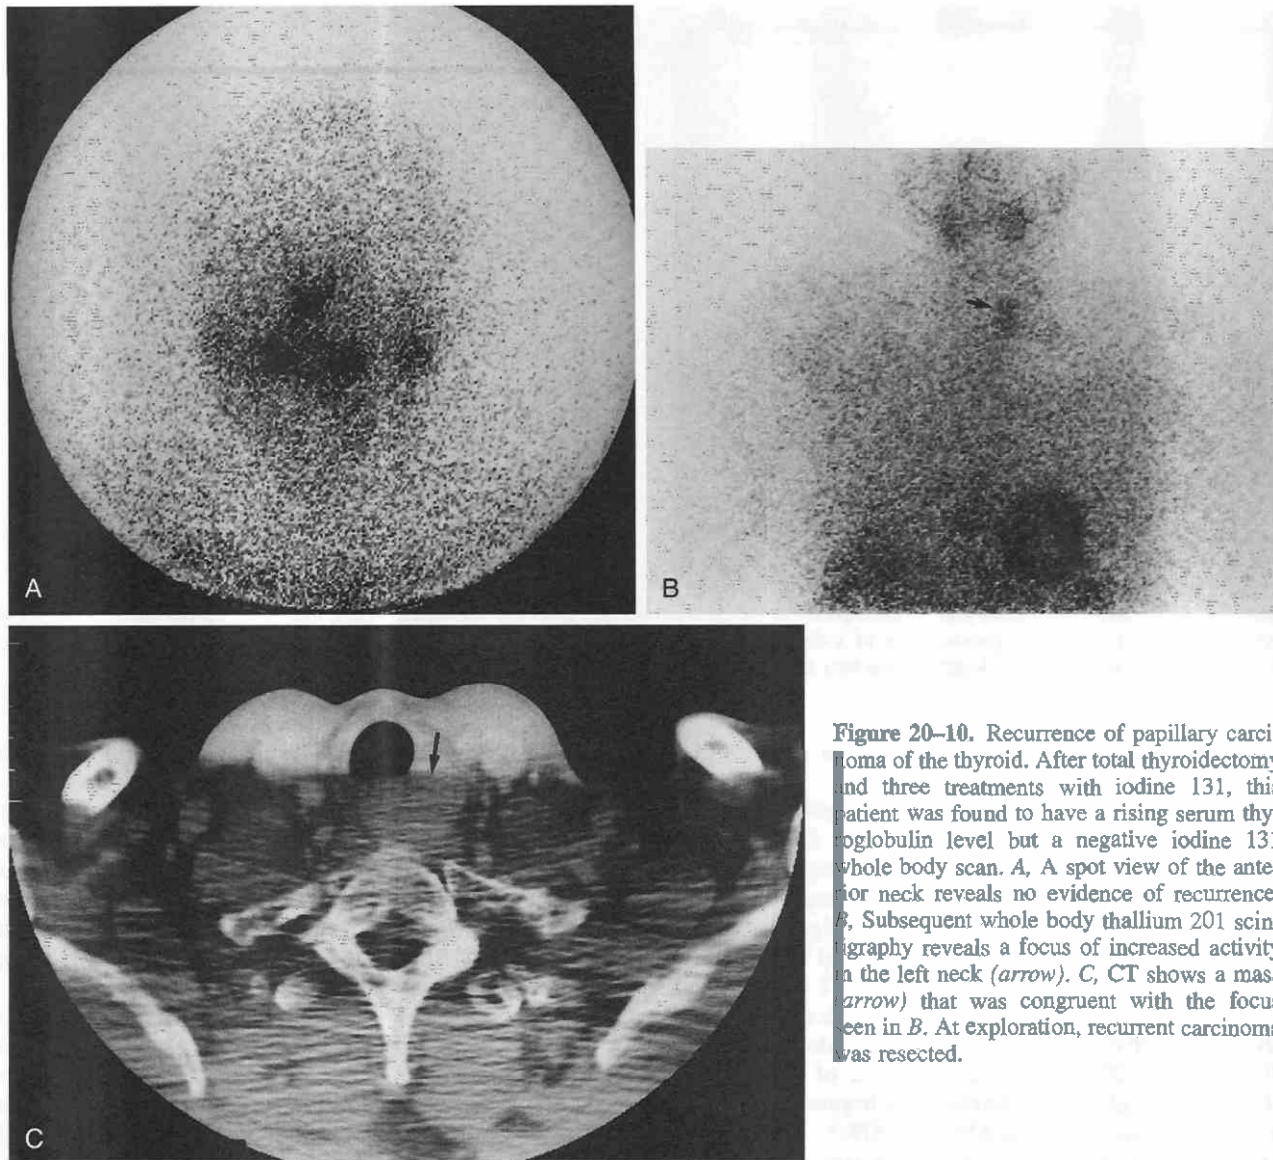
Recurrence of papillary carcinoma of the thyroid. After total thyroidectomy and three treatments with iodine 131, this patient was found to have a rising serum thyroglobulin level but a negative iodine 131 whole body scan. *A*, A spot view of the anterior neck reveals no evidence of recurrence. *B*, Subsequent whole body thallium 201 scintigraphy reveals a focus of increased activity in the left neck (arrow). *C*, CT shows a mass (arrow) that was congruent with the focus seen in *B*. At exploration, recurrent carcinoma was resected.
